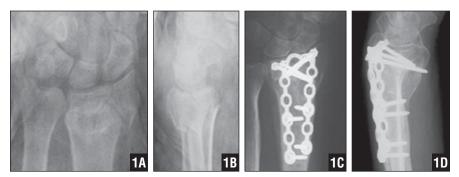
Preoperative AP (A) and lateral (B) radiographs of a type II fracture in a 42-year-old woman who sustained the fracture after a fall from a height. AP (C) and lateral (D) radiographs at last follow-up 91 months postoperatively. The Mayo score was 94.
